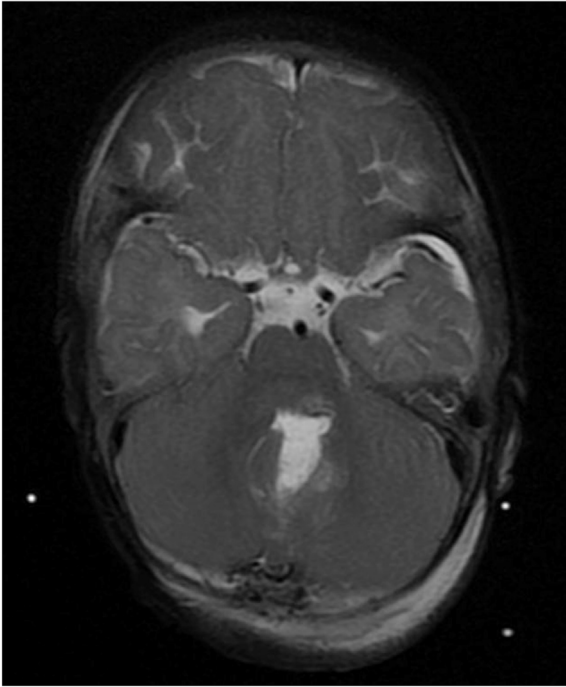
Postoperative axial T2 MRI of the completely resected lesion.
